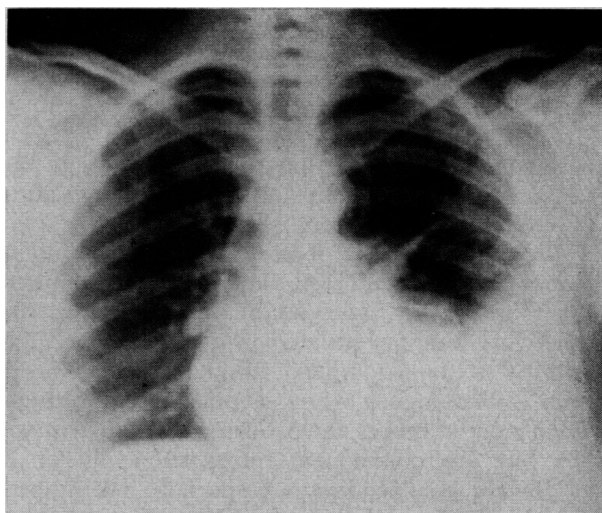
Admission chest radiograph in April 1959 showing homogeneous density in the left base suggestive of pleural fluid and/or thickening.
